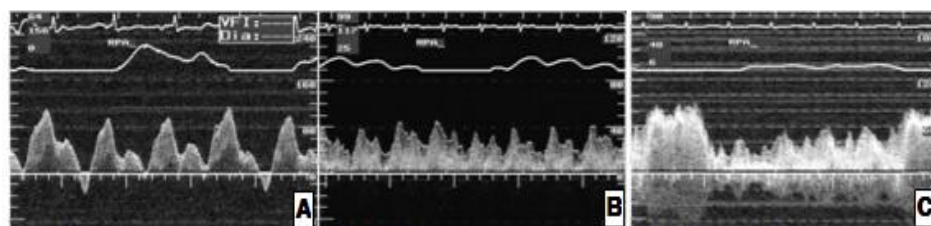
Intravascular Doppler spectrals at RPA in 3 groups (A;APC group, B;LTF group, C;ECF group)
